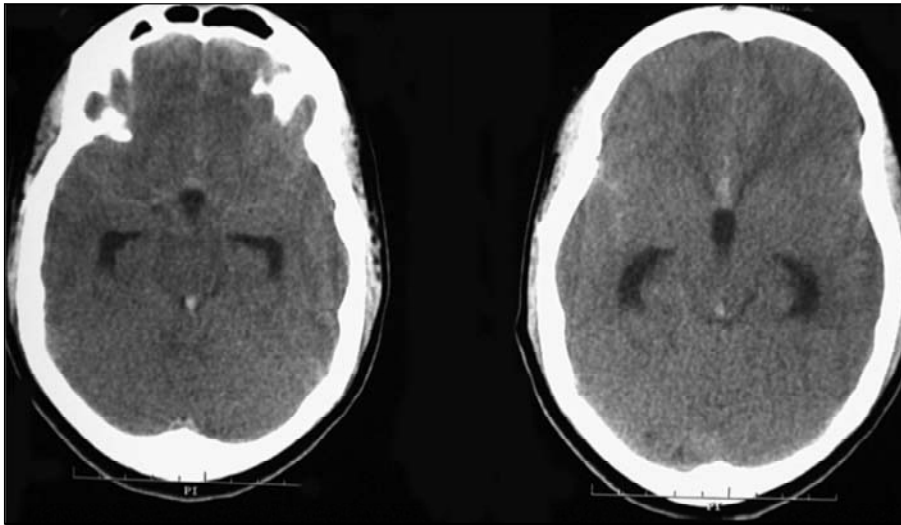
CT: subarachnoid hemorrhage Fisher grade II and hydrocephalus.
